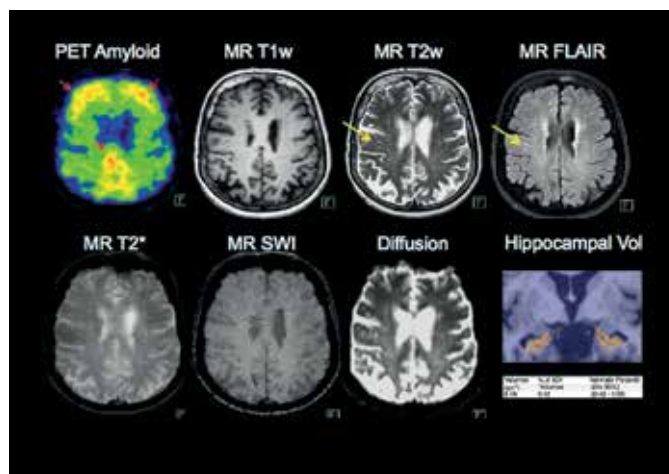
72 year old female patient suspected of Alzheimers Disease. Simultaneous PET/MRI acquisition shows significant cortical amyloid binding, an essential risk factor for Alzheimers Disease (red arrows). Clinical MRI shows discrete white matter lesions (yellow arrows) presumably older ischemic changes (T2w, FLAIR, Diffusion). There are no microbleedings (T2, SWI). The hippocampal volume is significantly reduced. The combinations of clinical presentation, increased amyloid binding and structural, neuronal damage would categorize the biomarker probability of Alzheimers disease as high.*
